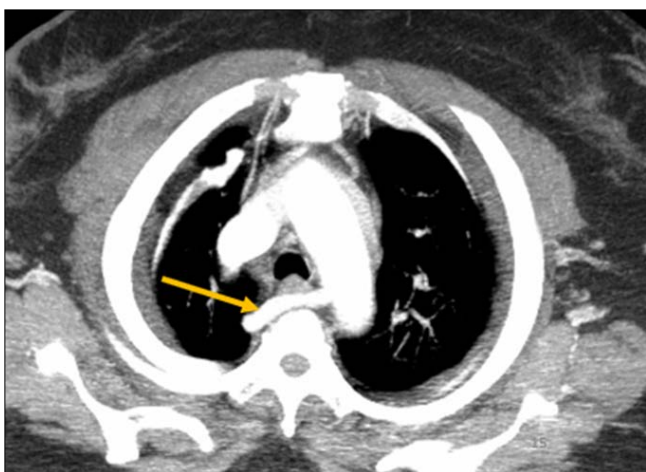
Angio-CT of the thorax in axial section of an arteria lusoria (orange arrow); (Type V de la classification de Natsis *et al.*).
